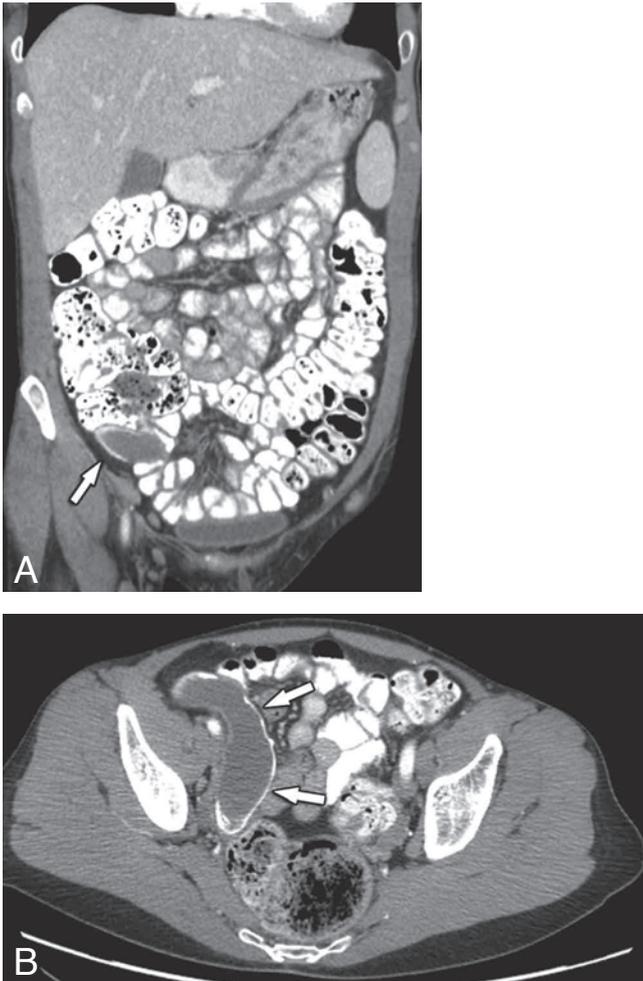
Coronal (A) and axial (B) CT scan shows the typical appearance of an appendiceal mucocele with cystic content and mural calcifications.
